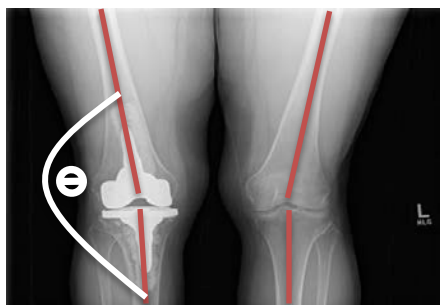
Measurement of the subject's tibiofemoral angle (Θ) from a posterior radiographic image.
